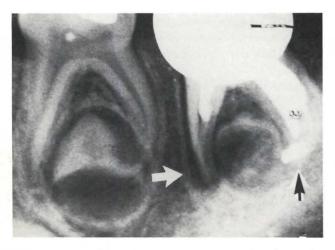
Immediate posttreatment periapical radiograph. Note overfilling and radiolucent lesions.
